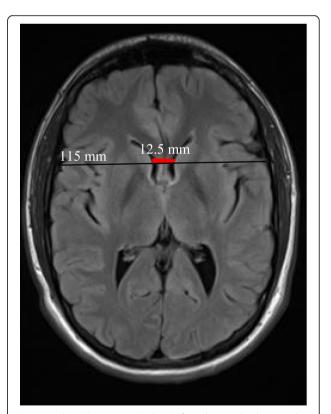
Axial FLAIR image at the level of caudate nuclei showing the bi-caudate ratio (the inter caudate distance (red line, 12.5 mm) divided by the while brain width at the same level (black line, 115 mm) (BCR = 0.11)
